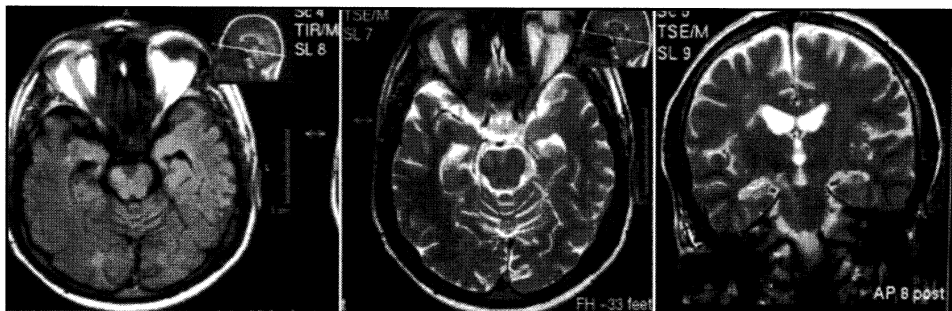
Axial FLAIR, axial T2-weighted image and coronal T2-weighted image showing typical neuro-Behçet's disease lesions extending from right thalamus to midbrain. Brainstem and cerebellar atrophy, and periventricular and subcortical lesions can also be noted. FLAIR: Fluid attenuated inversion recovery
